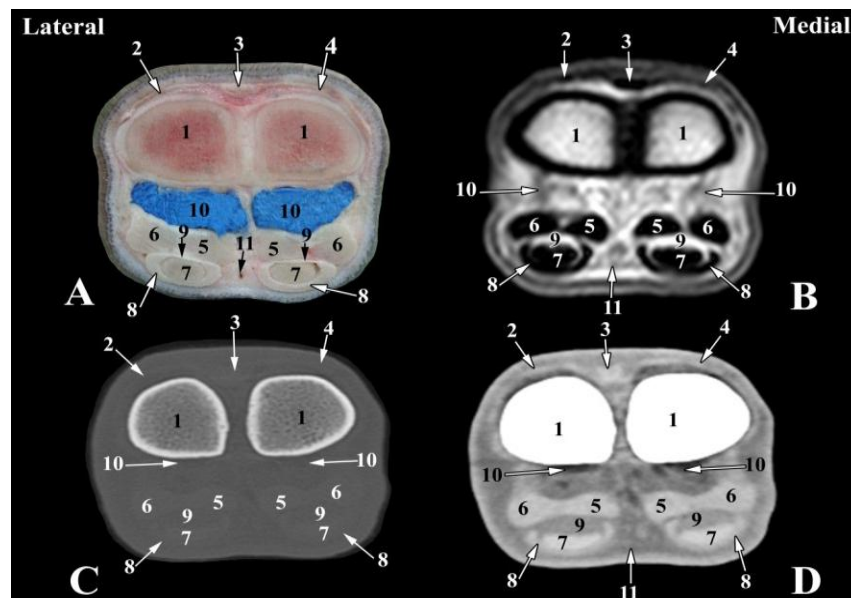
Transverse images of right fore fetlock joint of camel at the level of metacarpal/metatarsal trochlea (Level 1 as indicated in Fig. 1). A- Transverse anatomical section; B- Magnetic resonance image; C- Bone window computed tomography image; D- Soft tissue window computed tomography image: 1- Metacarpus; 2- Lateral digital extensor tendon; 3- Lateral limb of common digital tendon; 4- Medial limb of common digital extensor tendon; 5- Axial limbs of inter-osseous muscle; 6- Abaxial limbs of inter-osseous muscle; 7- Deep digital flexor tendon; 8- Superficial digital flexor tendon; 9- Manica flexoria; 10- Palmar synovial pouch of fetlock joint; 11- Common palmar digital artery.
